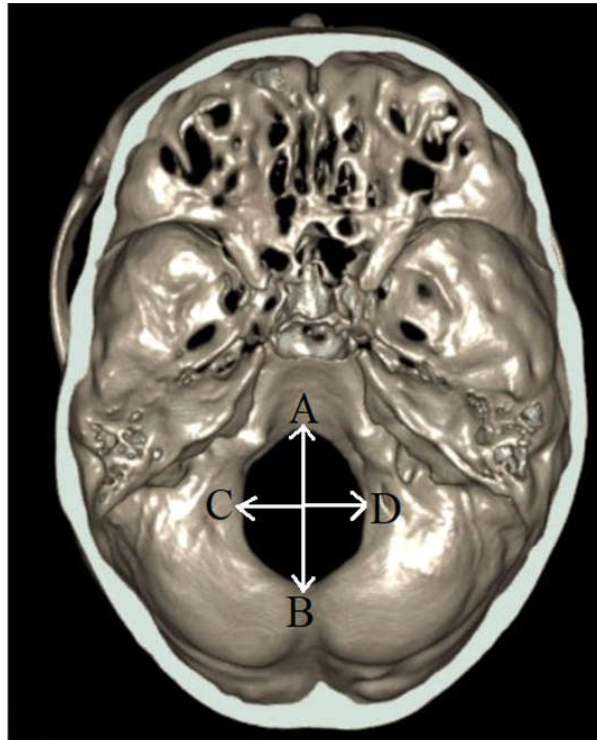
depicts measurement of dimensions of the foramen in 3-dimensional CT Scans.
